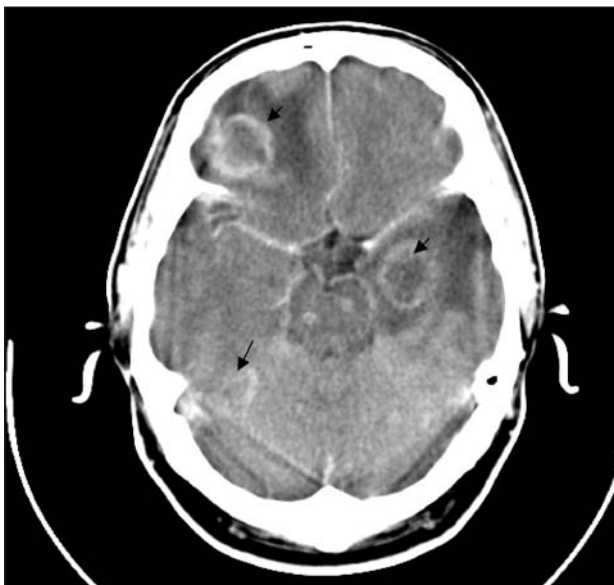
Shows multiple enhanced lesions as they were detected on computed tomography after contrast medium was introduced.
